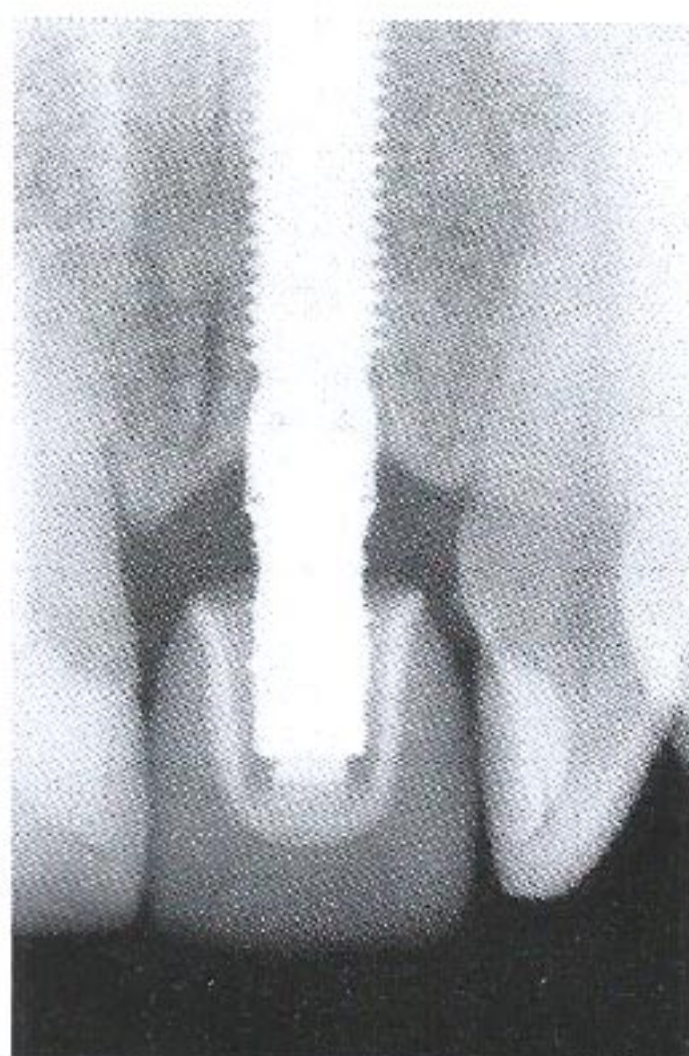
Radiograph of maxillary left central incisor area taken 3 years following abutment connection. The acetabular part of abutment is radio-transparent.
